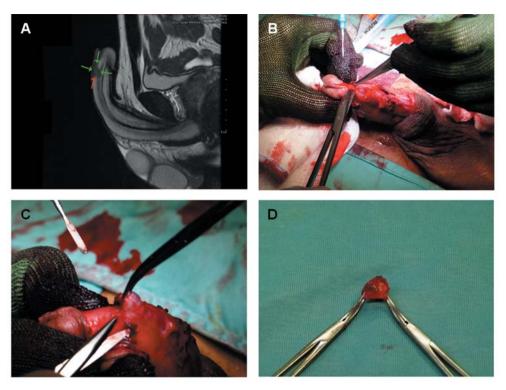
Magnetic resonance imaging of the penis showing the lesion (surrounded by arrows) of the penile shaft (panel A); isolation (panel B) and surgical excision (panel C) of the mass; the gross appearance of the excised nodule (panel D).
